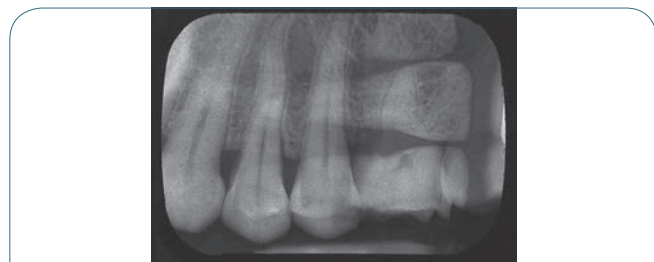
Double exposure. Film was exposed twice with each exposure shown on the x-ray film.
